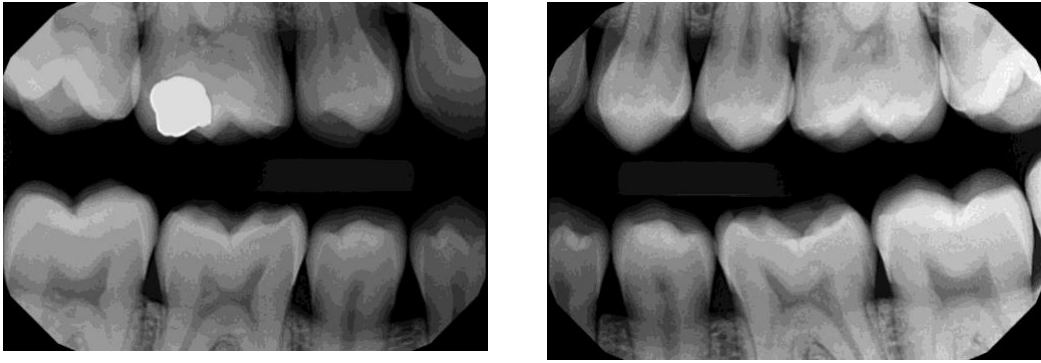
right and left bitewing radiographs 01/11/2019
